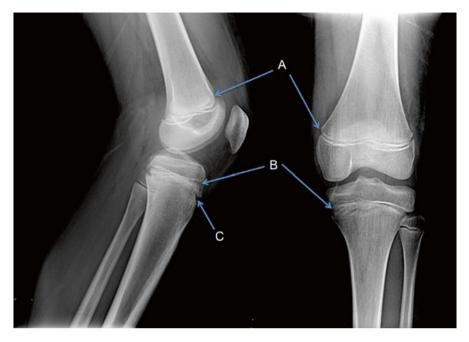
Lateral and AP radiographs of the pediatric knee. (A) Distal femoral physis, (B) proximal tibial physis, (C) tibial tubercle apophysis, and attachment of the patellar tendon
